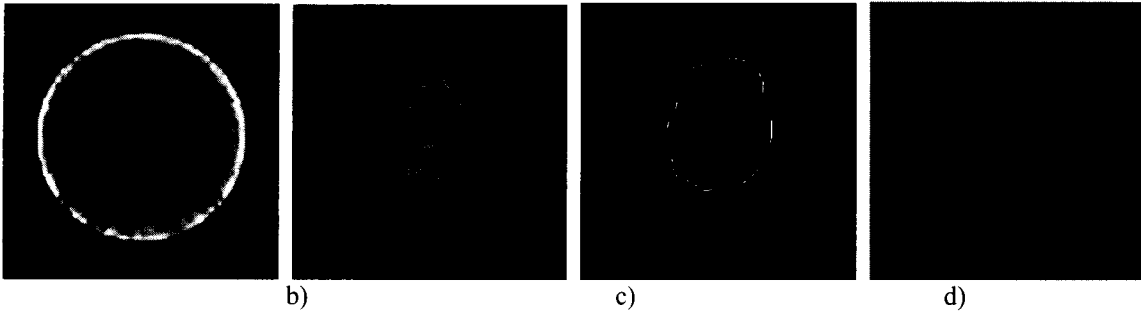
Distance transform with SPECT scan
